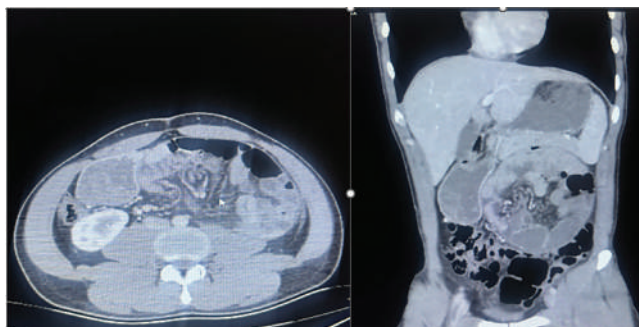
Hernia defect area. CT scan showing internal herniation.
